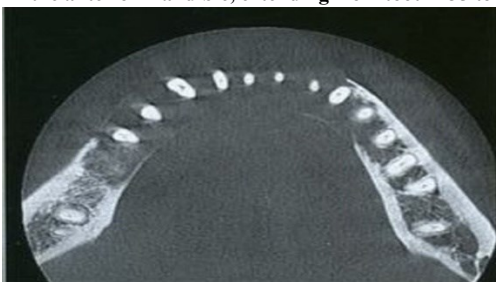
Cone-beam computed tomography revealing an osteolytic lesion causing destruction of mandibular buccal and lingual cortices
